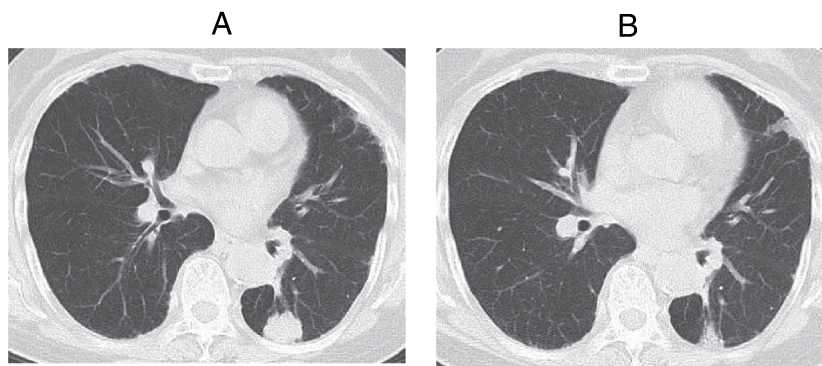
Chest computed tomography scans before and after alectinib treatment. After new lesions developed following 2 years of cytotoxic chemotherapy, alectinib treatment was initiated (A). Two months later, the tumor sizes were markedly reduced; moreover, no interstitial lung disease was detected (B).
